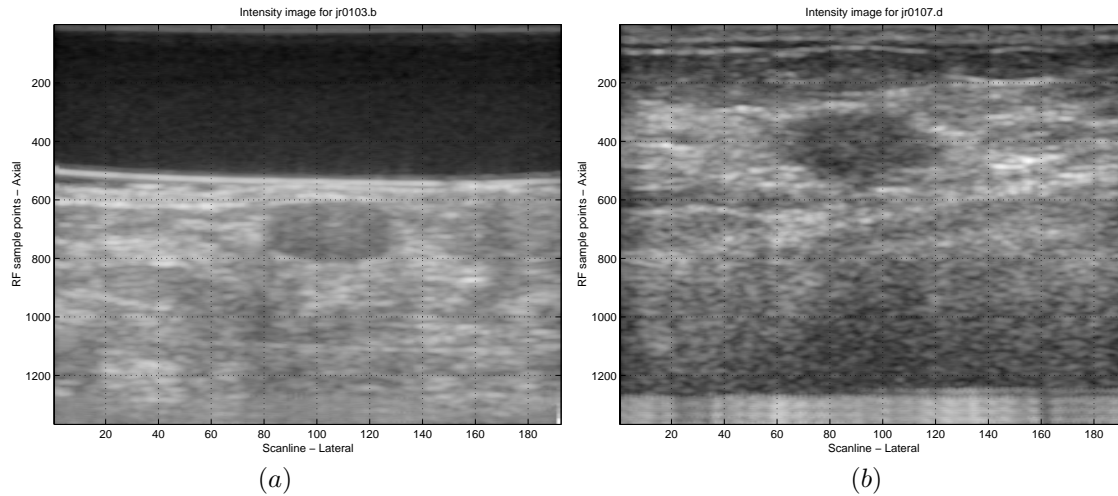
Ultrasound B-Scan images for (a) a benign case (b) a malignant case.
